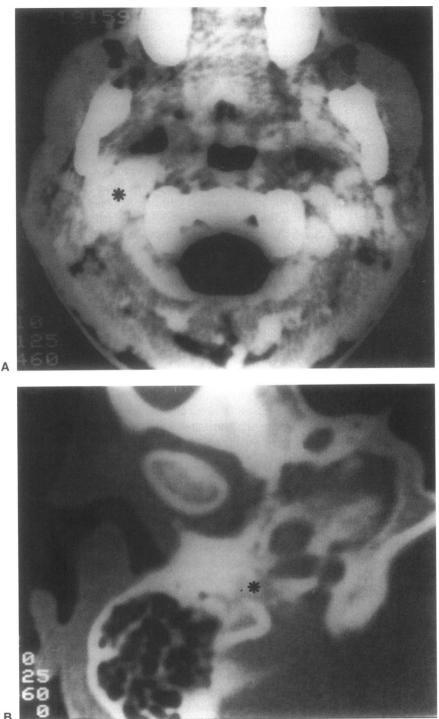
Vagal paraganglioma with intratemporal extension on the left side (case 3). A. Preoperative axial CT with contrast showing the tumor in the neck (*). B. Preoperative axial CT with contrast showing the intratemporal tumor extension (*). (Figure continued on the next page.)
